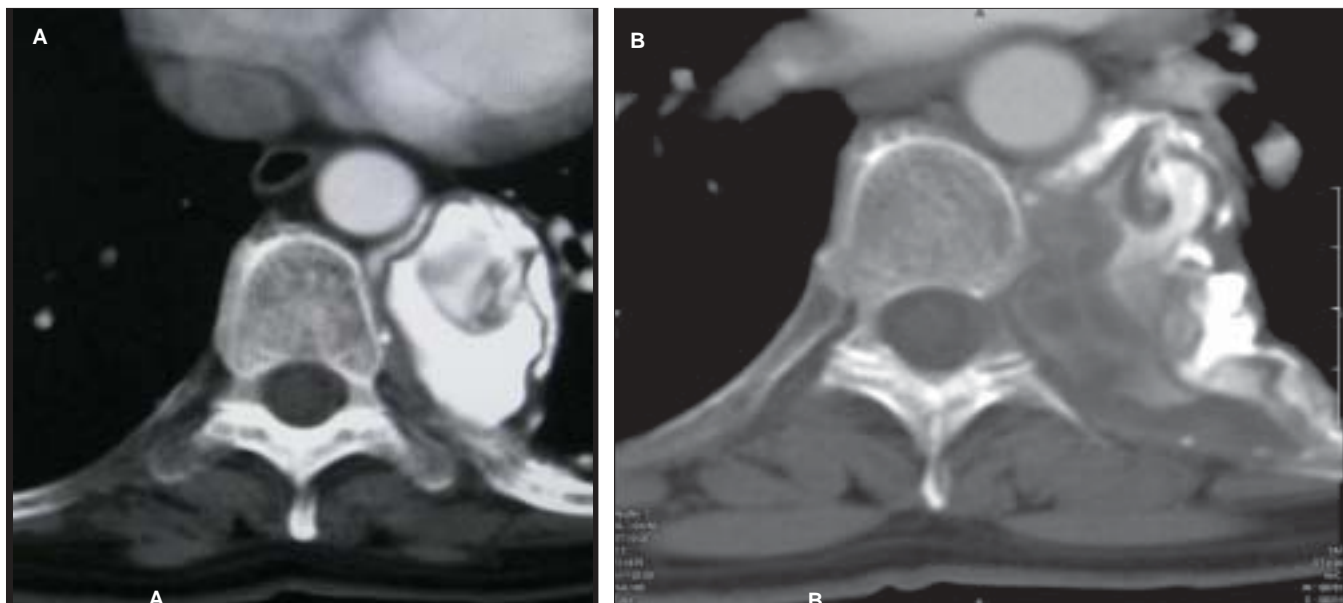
(A, B): Axial contrast-enhanced CT of the chest
